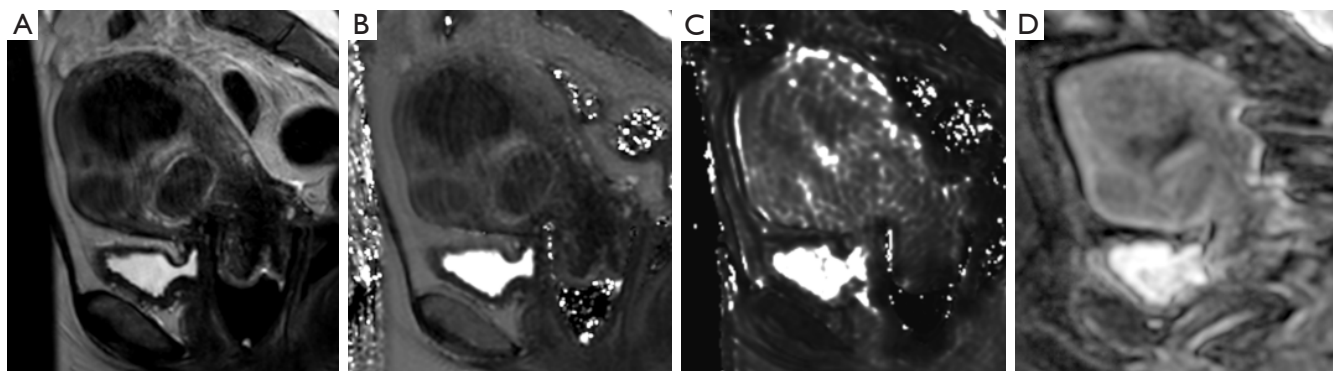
Sample parameter maps obtained from mp-qMRI are shown. (A) A sagittal T2-weighted image and corresponding quantitative parameter maps: (B) T2, (C) T2*, and (D) ADC are shown for the same slice through the uterus of the 42-year-old patient whose image is shown in Figure 2. mp-qMRI, multiparametric quantitative magnetic resonance imaging; ADC, apparent diffusion coefficient.
